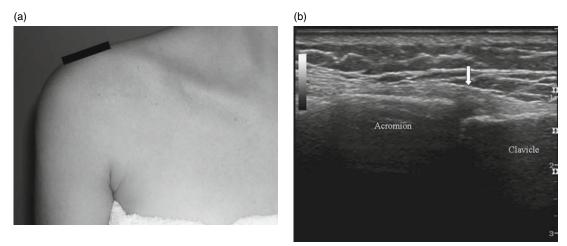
Acromioclavicular joint: (a) transducer position and (b) corresponding ultrasound image in the coronal axis. Arrow, joint capsule and superior acromioclavicular ligament.
